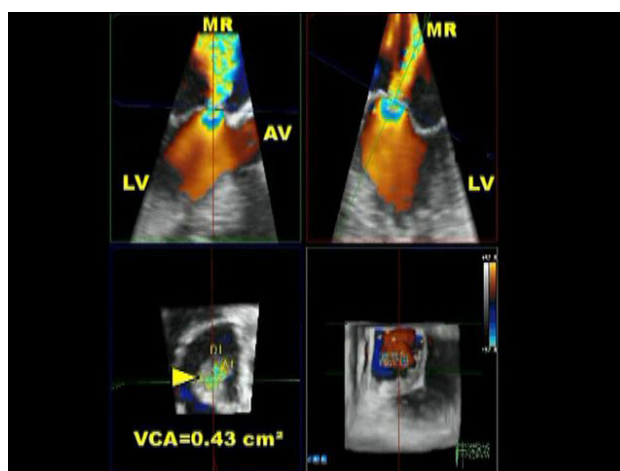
Live/real-time three-dimensional color Doppler transesophageal echocardiographic technique for assessment of VCA. The three-dimensional dataset is cropped at the level of the MR vena contracta (MR jet origin) and cropped to view it en face (arrowhead). VCA measured 0.43 cm², indicative of severe MR. VCA: vena contracta area; LV: left ventricle; MR: mitral regurgitation; AV: aortic valve. Copyright with Navin C. Nanda
